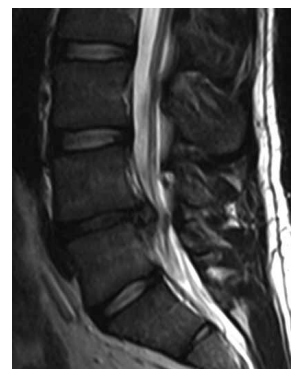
Preoperative MRI shows disc hernia with accompanying degenerative changes of intervertebral segment.
